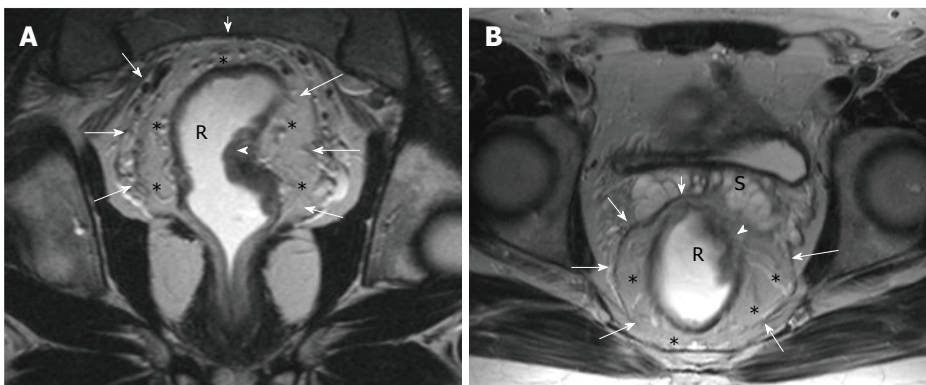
Magnetic resonance imaging anatomy of mesorectum and mesorectal fascia. On T2-weighted (A) axial and (B) coronal plane magnetic resonance images, mesorectal fascia (arrows) is seen as a thin, low-signal intensity layer enveloping the mesorectal fatty tissue (*) and rectum in a male patient with rectal carcinoma.
